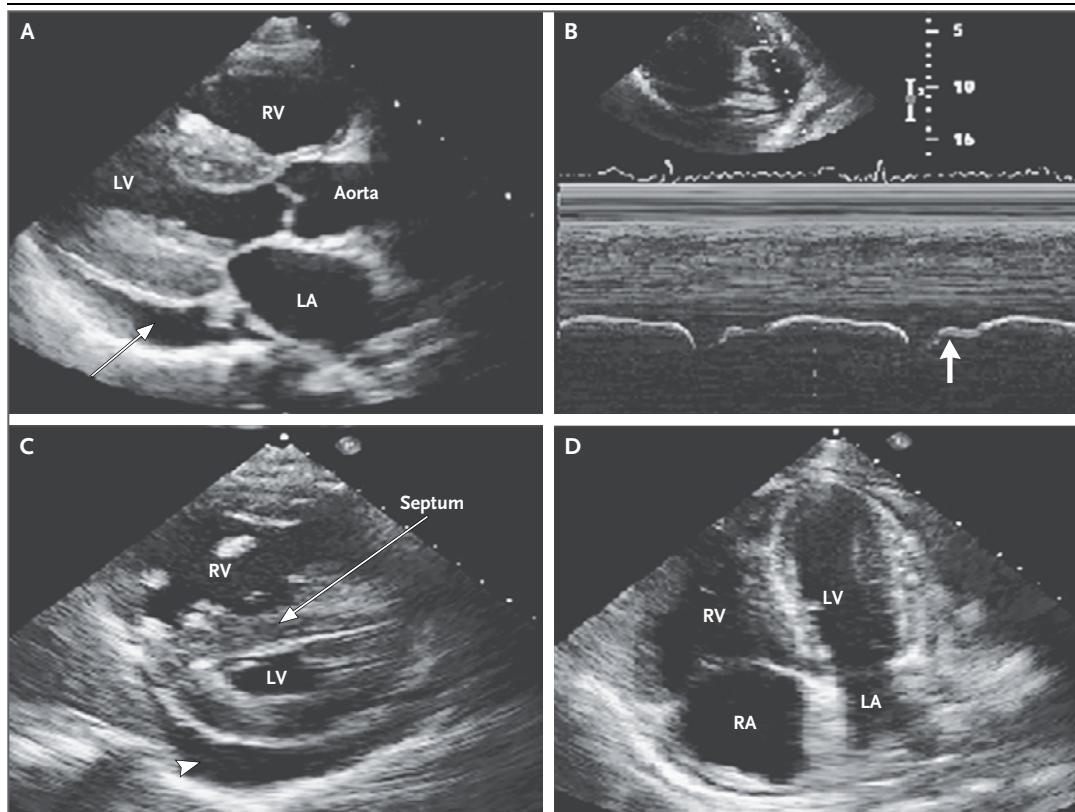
Echocardiographic Imaging.
